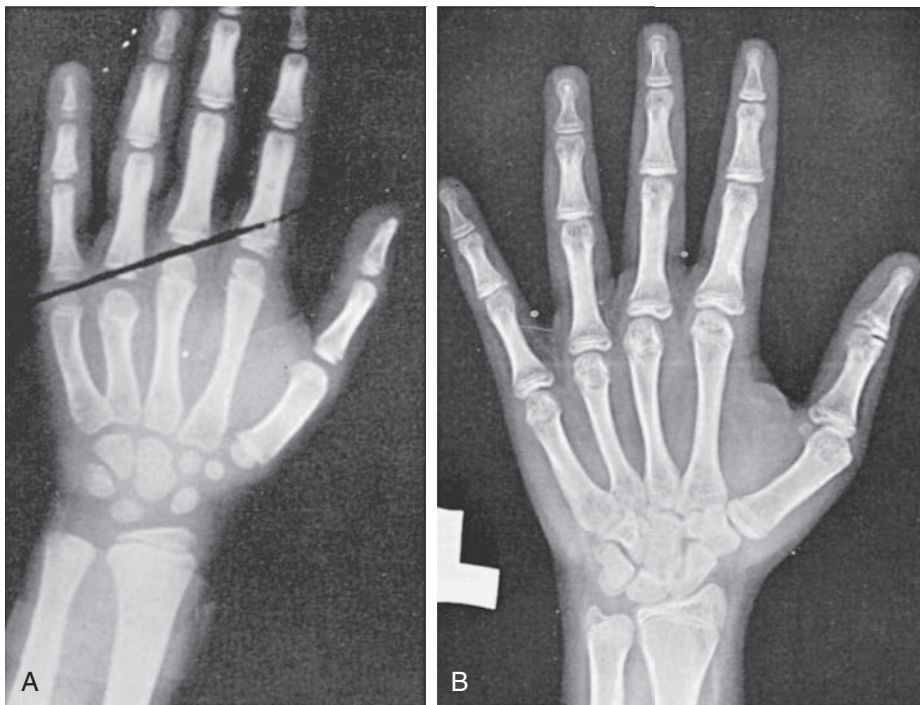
■ Two characteristic hand radiographs. A, Short fourth metacarpal, the tip falling below a straight line drawn between the third and fifth metacarpals. B, Generalized lacy ("fish net") appearance of the carpals and tufting of the distal phalanges, characteristic of the osteoporotic appearance of the bones of patients with Turner syndrome.
